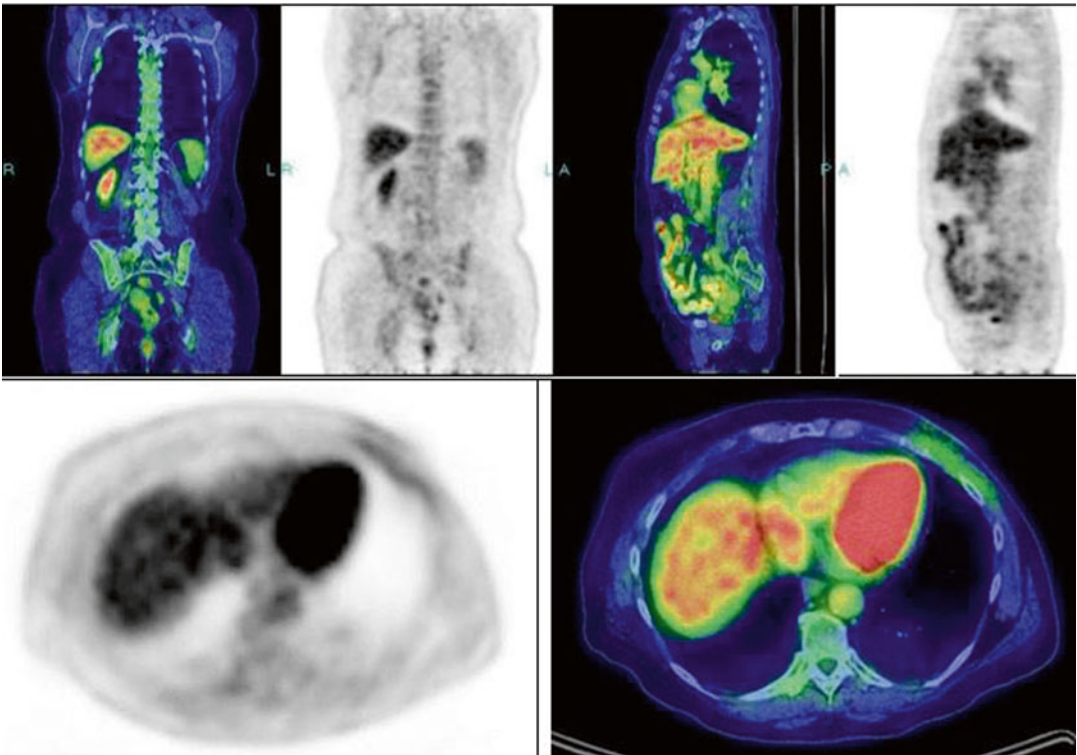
PET/CT (posttreatment/surgery)
